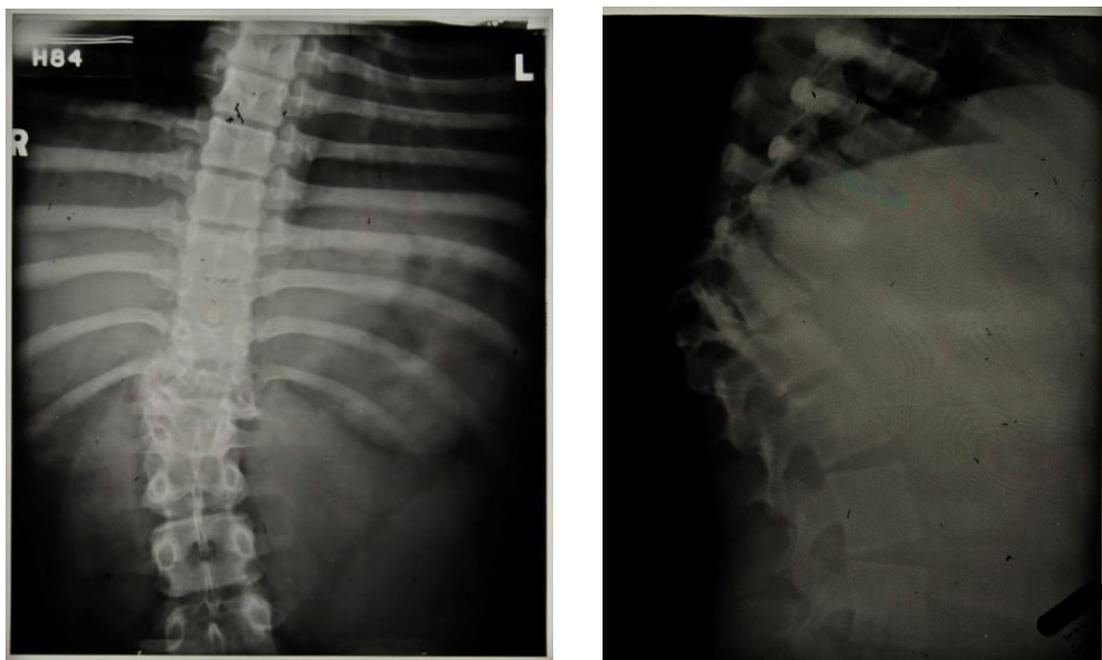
Patient 87/62 Radiograph report 13th June 1941: 'Good consolidation. Right psoas becoming calcified' (HOSP/STAN/7/1/2/487_02 & 03)
